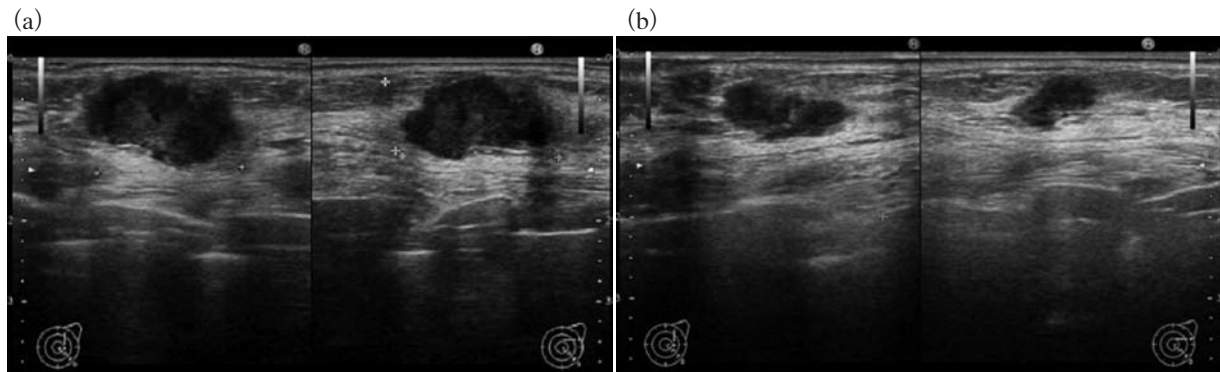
(a) Ultrasonography before the patient started flutamide revealed an irregularly shaped, hypoechoic mass with an indistinct margin measuring $19 \times 18 \times 9$ mm located at the upper outer quadrant of the left breast. (b) After 8 months treatment with flutamide, the size of the tumor had reduced to $15 \times 9 \times 5$ mm.
